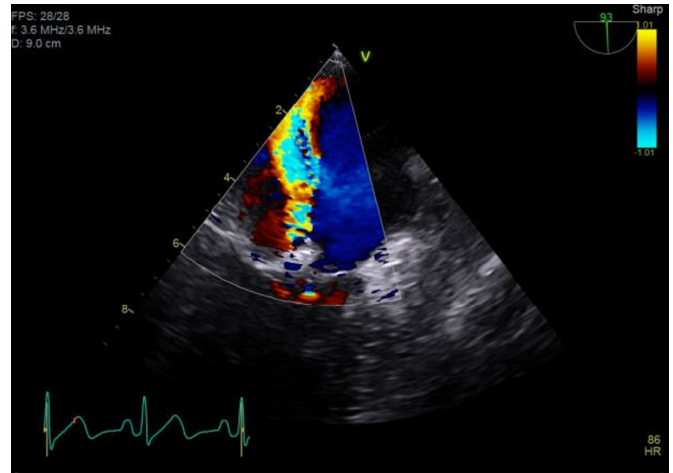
Transoesophageal echocardiogram showing severe mitral regurgitation.
